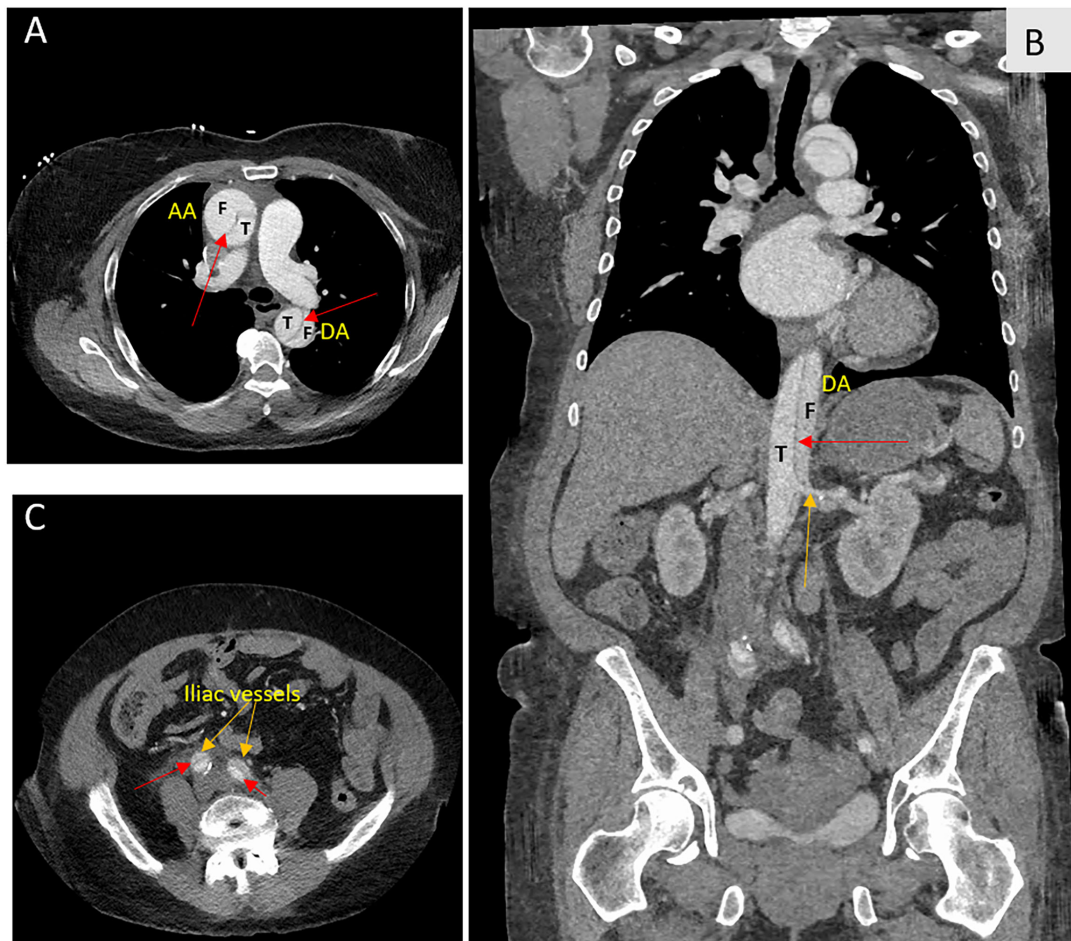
Dedicated computed tomography angiography of the aorta demonstrating an aortic dissection involving the ascending and descending thoracic aortas (A), the abdominal aorta (B), and the iliac vessels (C). Red arrows indicate the dissection flaps. The orange arrow in (B) highlights the left renal artery arising from the true lumen of the abdominal aorta. AA = ascending aorta; DA = descending aorta; F = false lumen; T = true lumen.
